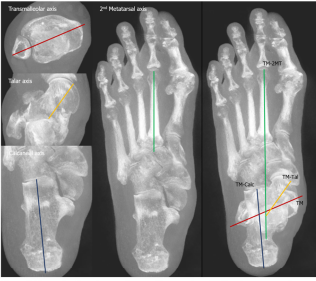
Determination of axes of bones of interest in weightbearing computed tomography. The angle of rotation for each axis was assessed in relation to the transmalleolar (TM) axis. TM, transmalleolar.
